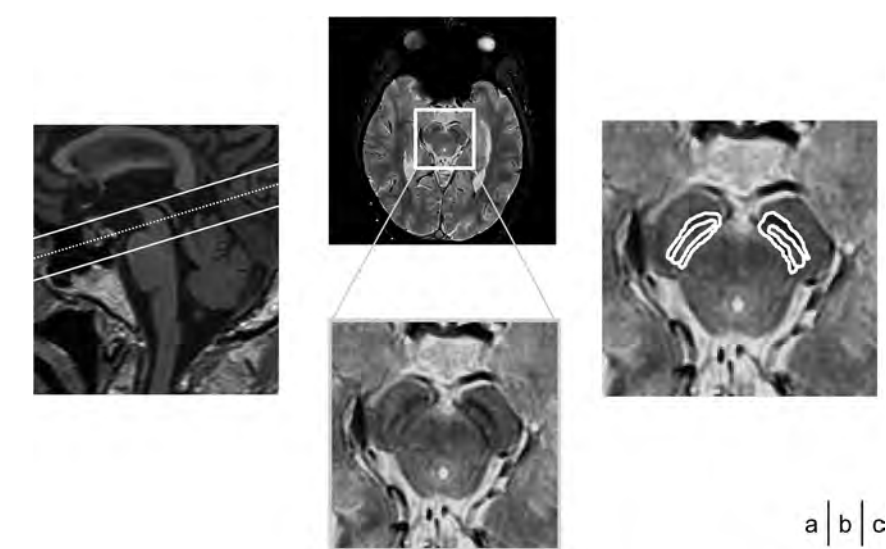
The 3D spoiled gradient-echo sequences with multiecho acquisitions are oriented orthogonally to the anterior midbrain (A), and nigrosome 1 is visualized in the caudal and mediolateral part of the substantia nigra pars compacta (B). When the subjects' heads were tilted to the right or left, the MR imaging signal intensities measured on the basis of the depicted ROI (C) differentiated nigrosome 1 and SNc.
